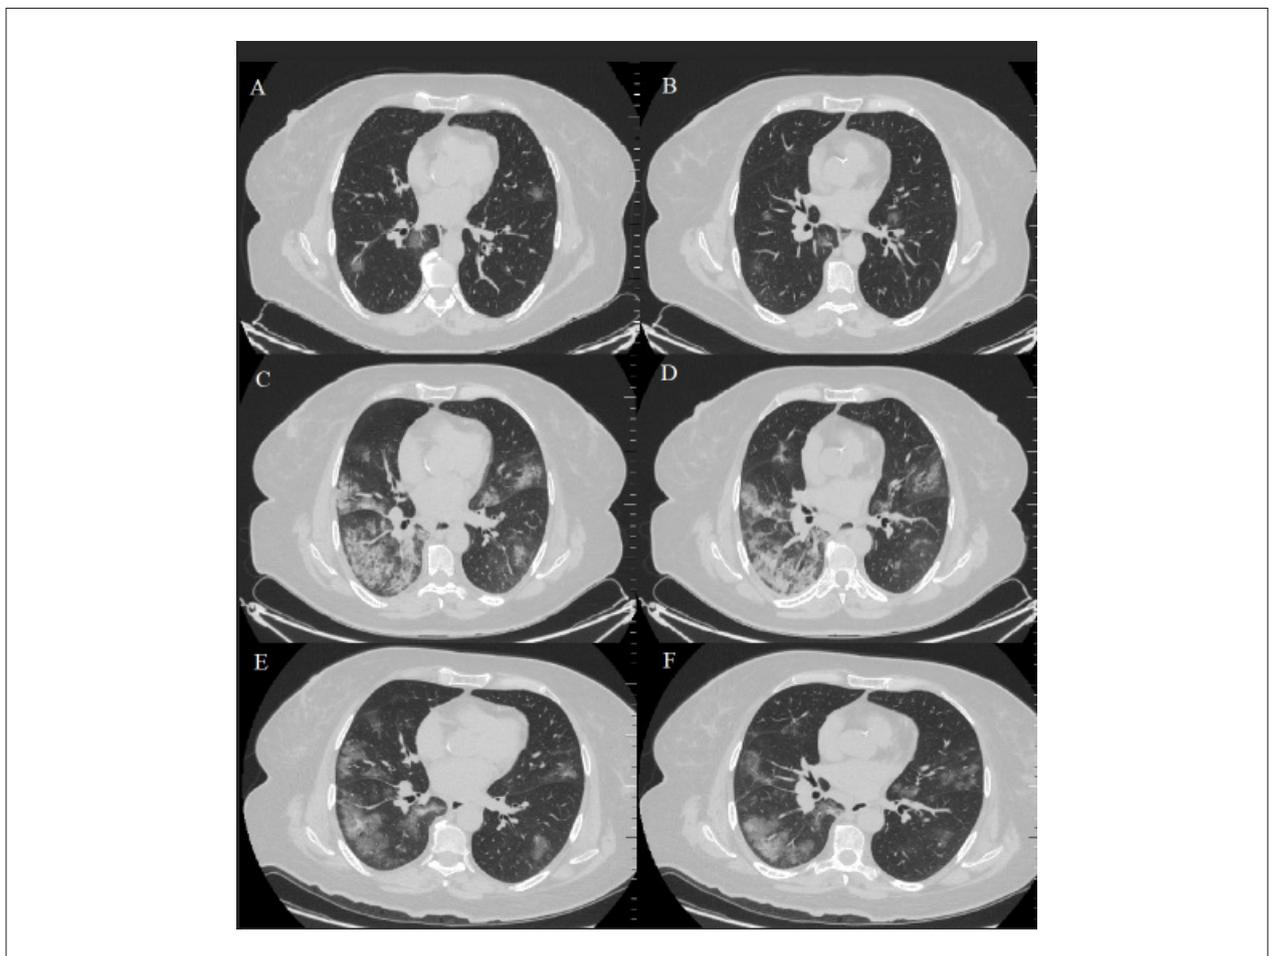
Axial CT images. (A-B): At admission, CT shows the bilateral presence of mild GGOs in the parenchyma. (C-D): On day 6, a repeated CT was consistent with increasing expansion of the GGOs and progressed consolidations, which are called crazy paving consolidations. (E-F): On day 12, a repeated CT showed that the previous consolidations and GGOs in both lungs were mostly absorbed, leaving fibrous lesions that may indicate residual organizing pneumonia. CT: computer tomography, GGOs: ground-glass opacities.
